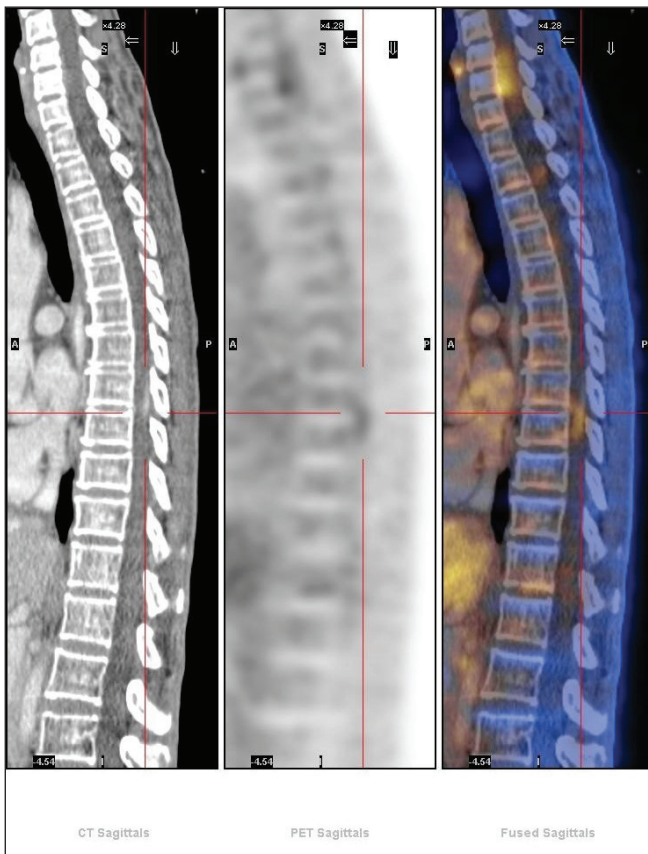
FDG avid ill-defined intra-spinal enhancing lesions at D8-D9 level.
